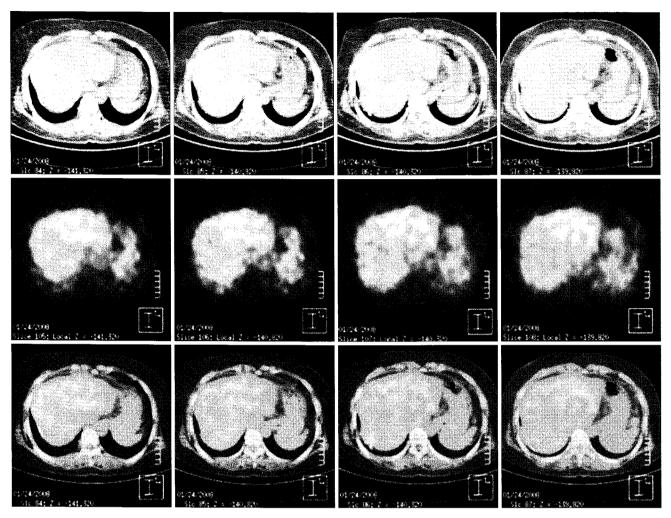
PET-CT scan of 53 year-old female hepatocelluar carcinoma patient (case 1) before hepatic irradiation. There was diffuse increased ¹⁸F-fluorodeoxyglucose uptake in the left lobe and the standard uptake value (SUV) was slightly higher than that of the right lobe (SUV of left lobe, 2.0; SUV of right lobe, 1.5).
